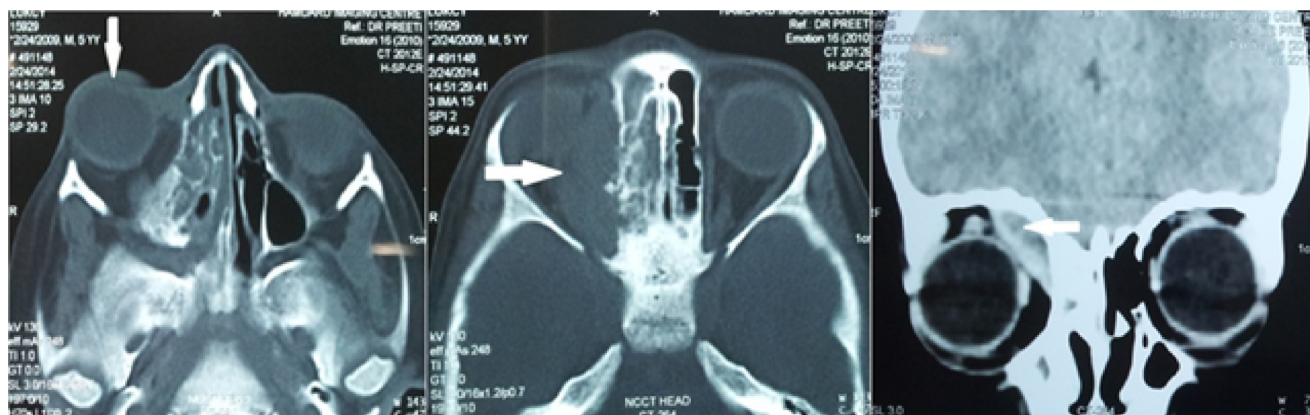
CT cuts showing right proptosis and periorbital abscess.
